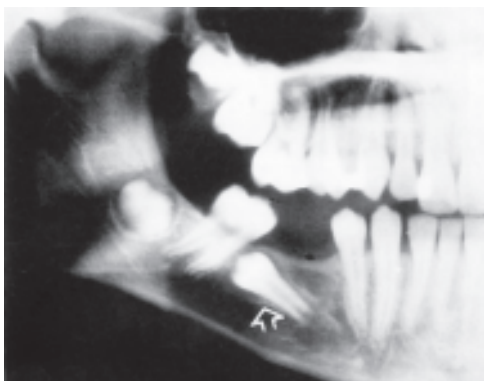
Panoramic radiograph showing distal drift of a wandering 5 (arrowed)
